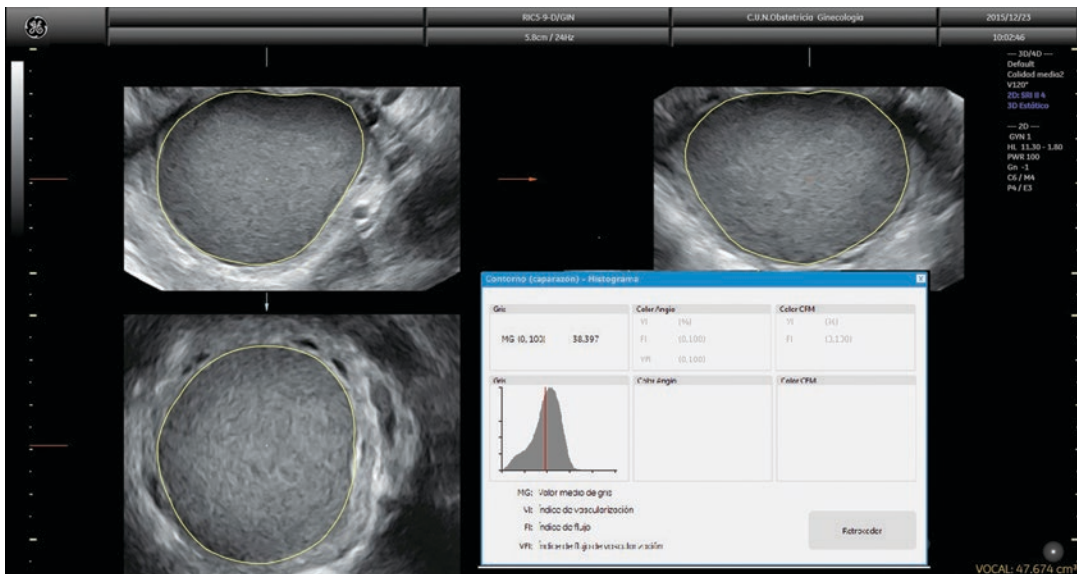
Three-dimensional ultrasound showing mean gray value calculation from the cyst content in a case of ovarian endometrioma
